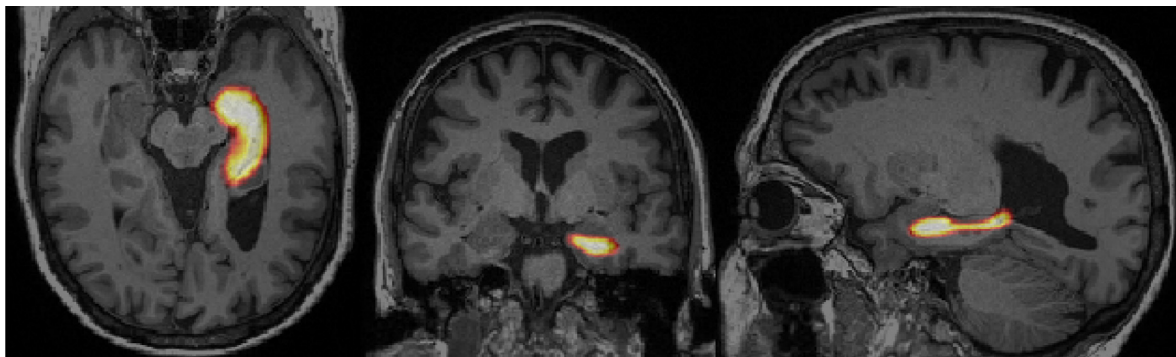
The probabilistic volume of interest (PVOI) for the left hippocampus is shown as a semi-transparent overlay in “hot” colormap on axial (left), coronal (middle) and sagittal (right) sections through a 3D structural MRI scan in native space.
